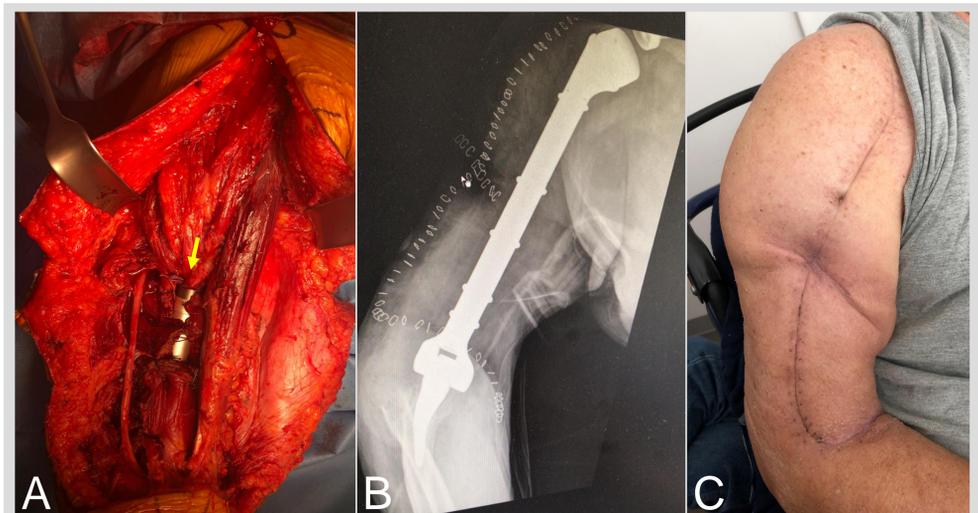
(A) Right upper arm from anterior. The total humerus prosthesis is distally covered by remnant brachialis muscle. The deltoid muscle is directly reattached (arrow) on the prosthesis. (B) Antero-posterior radiograph showing the total humerus prosthesis. (C) Clinical picture of the right upper arm after stitch removal three weeks after surgery. The transverse incision in the middle of the scar is due to elliptical excision of the biopsy paths.
